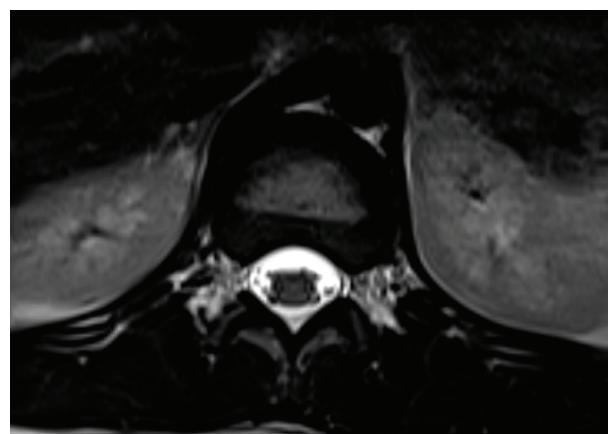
Axial T2 MRI, thoracic region, shows that just little extradural CSF accumulation (after three months)
